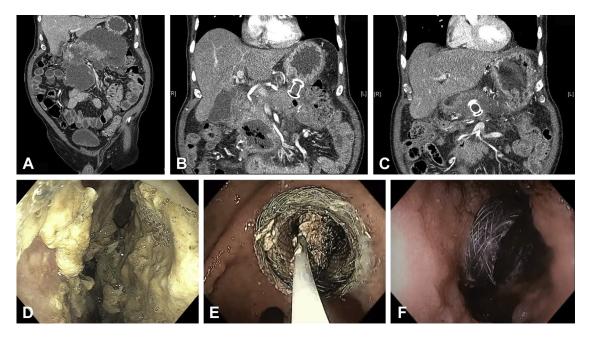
A, Coronal CT image showing extensive, complex, walled-off pancreatic necrosis. B, C, Coronal images showing locations of both lumen-apposing metal stents (LAMSs) within the cavity. D, Necrotic tissue within the cavity. E, Removal of necrotic tissue by use of a snare. F, The distal LAMS visualized within the cavity after final necrosectomy.
